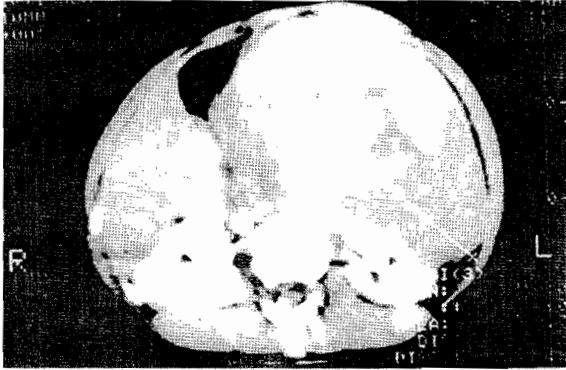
CT scan showing the location and size of the tumour.
